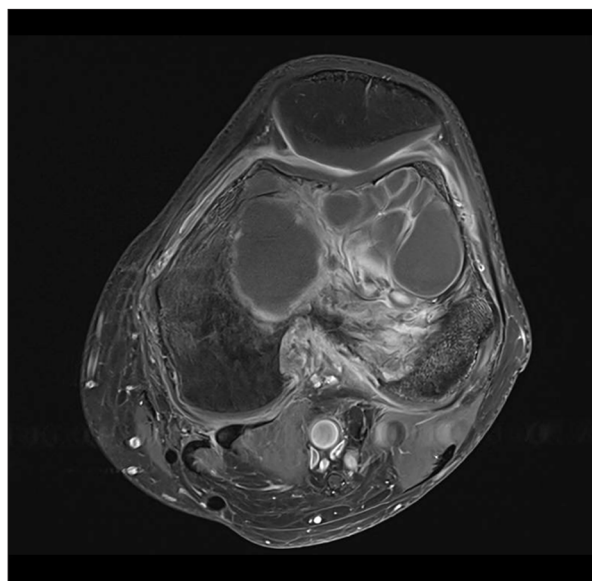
Preoperative T1- weighted MRI showing an osteolytic lesion of the left femur, with a mixed tissue and cystic component, invading the soft tissues and associated with a fracture line in the intercondylar notch. MRI, magnetic resonance imaging.
